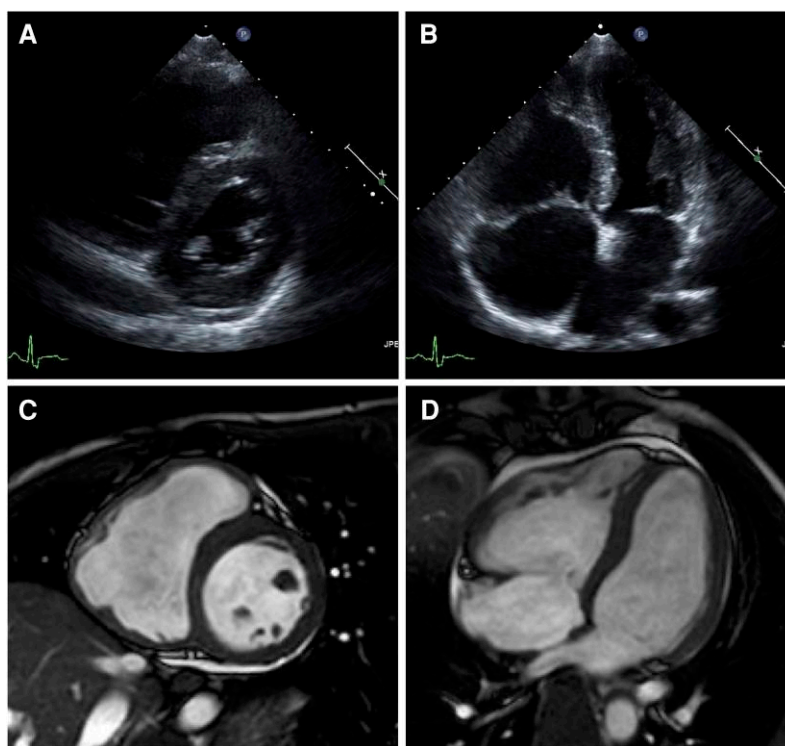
Right ventricular parameters on echocardiography and cardiac magnetic resonance (CMR) imaging. (A) and (B), both obtained from echocardiography, showed flattening of the interventricular septum at end-systole. (C) and (D), both obtained from CMR imaging, showed right ventricular dilatation and systolic dysfunction (right ventricular ejection fraction = 16%, right ventricular end-diastolic volume = 143.0 mL, and right ventricular end-systolic volume = 120.4 mL).
